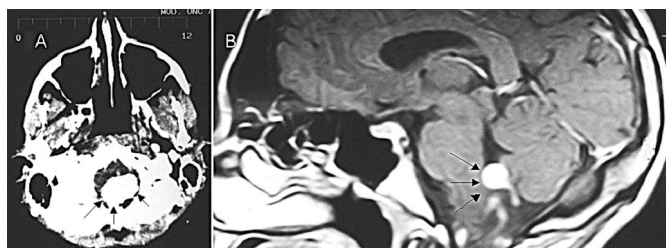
Contrast CT of Case 1 (A) and MRI of Case 2 (B), showing both the hemangioblastomas (arrows) growing in the obex area of the medulla oblongata.
